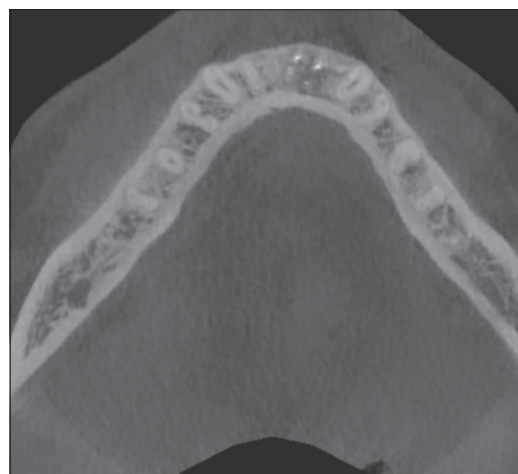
cone-beam computed tomography axial view demonstrating at 6 months the facial contours have been restored by osseous grafting of the large defect with Bond Apatite®
